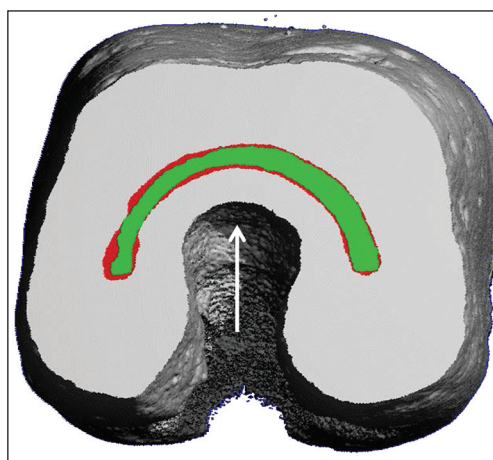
“Danger zone” in a C-shaped canal. This C-shaped canal was instrumented with the SAF System. Green: Before; red: After. If such a canal was treated with ultrasonic files, the only current effective alternative, the chance of excessively thinning the wall or even causing a strip perforation in the area marked by the arrow would be high. Such danger zones cannot be recognized from within the root canals or from periapical radiographs. Minimally invasive shaping with the SAF System represents a safe alternative
